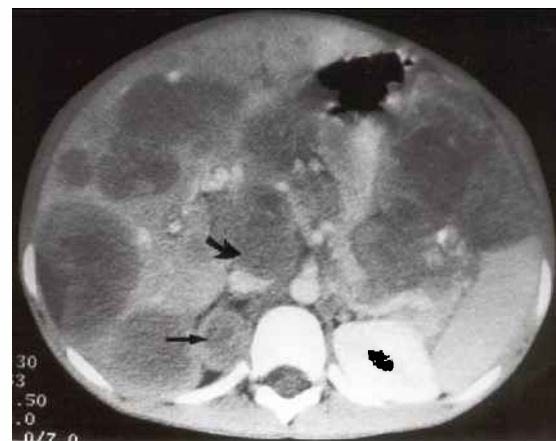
Contrast-enhanced CT image of the abdomen shows a soft tissue mass lesion in right adrenal gland (arrow), peripancreatic lymphadenopathy (curved arrow) and multiple hypodense lesions in the liver.
